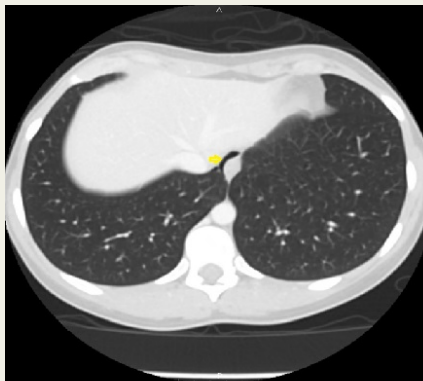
CT thorax revealing free air around distal esophagus (see yellow arrow)
